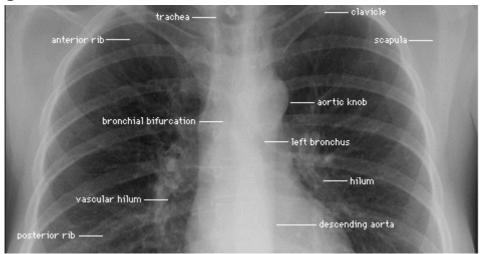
Plain radiograph of thorax, posteroanterior view
